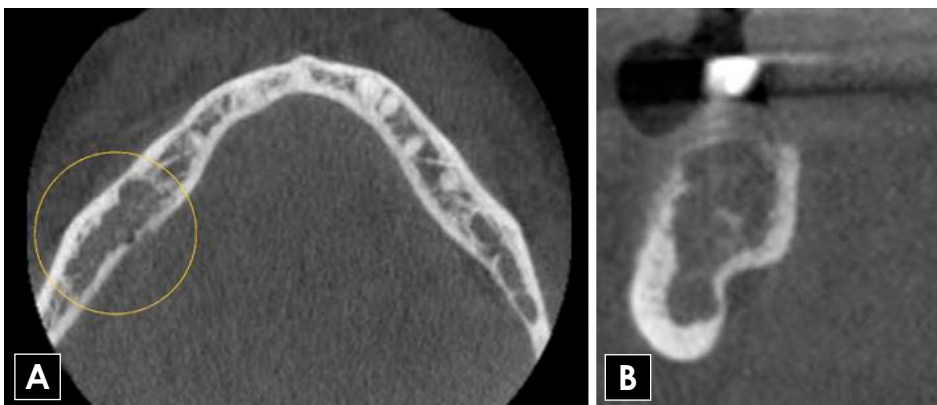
Axial (A), and coronal (B) CBCT images indicate an ill-defined low-density lesion without expansion involving the posterior right side of the mandible. CBCT: cone-beam computed tomography.
